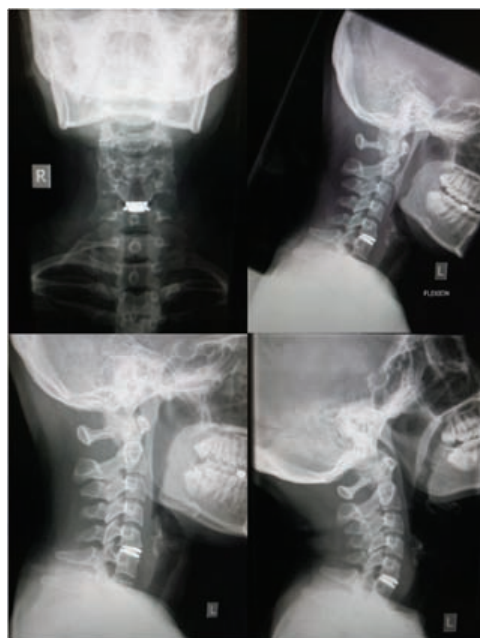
X-ray of Case #1 at 2 year follow up showing lack of heterotopic ossification (HO) and spontaneous fusion, at the level of the treated segment
